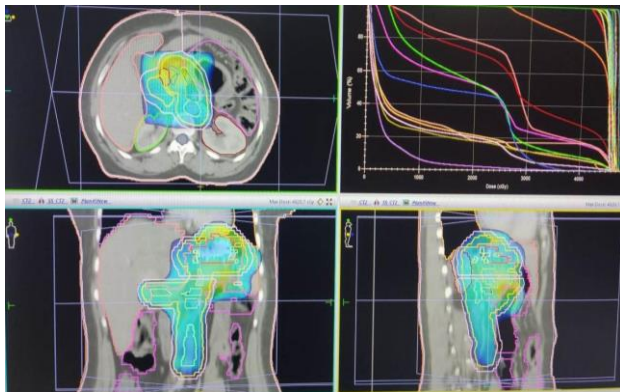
Isodose color wash on CT image (3DCRT plan).
